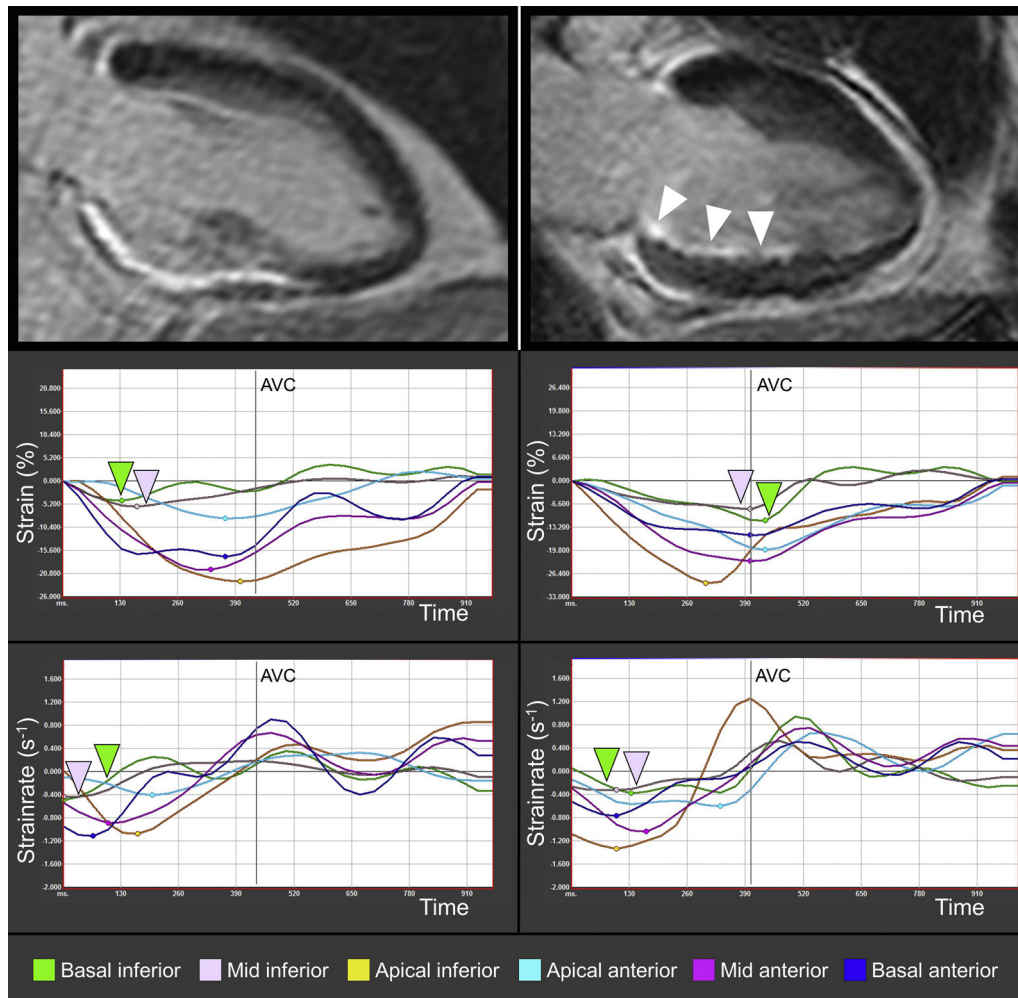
Patient examples with different levels of infarct transmurality. DE CMR images showing a transmural MI (85%) of the basal-mid inferior segments (*top left*) with abnormal strain and SR (*middle and lower left*) and a subendocardial (14%) MI of the basal-mid inferior segments (*white arrowheads; top right*) without convincing regional SWMAs but with abnormal strain and SR (*middle and lower right*). Supplemental corresponding echocardiographic cine loops (*Videos 1 and 2*) are available online. AVC, Aortic valve closure.
